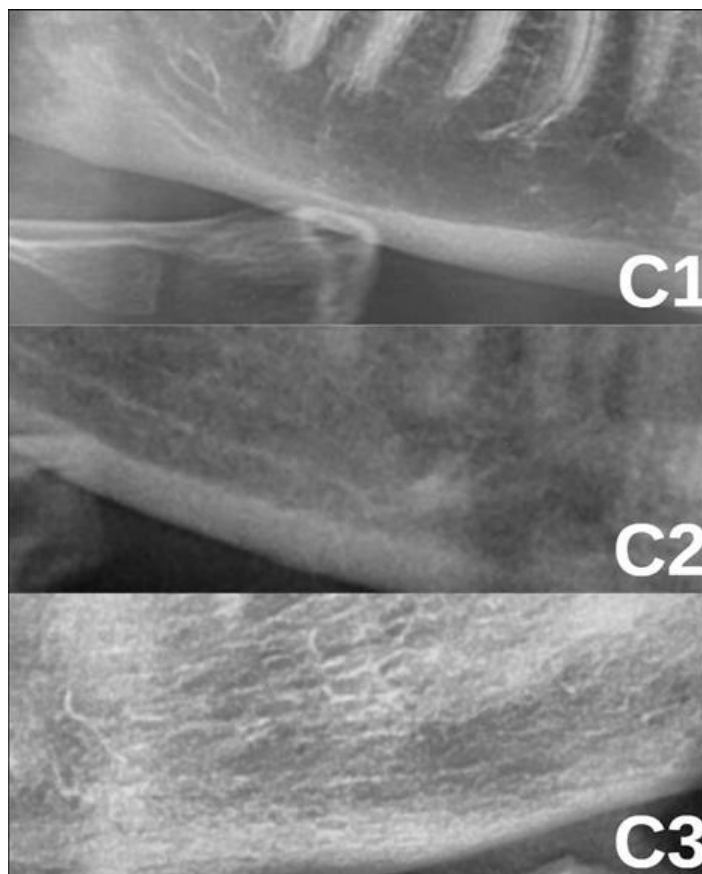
Radiographic presentation of mandibular cortical index classification. C1, C2, and C3.
